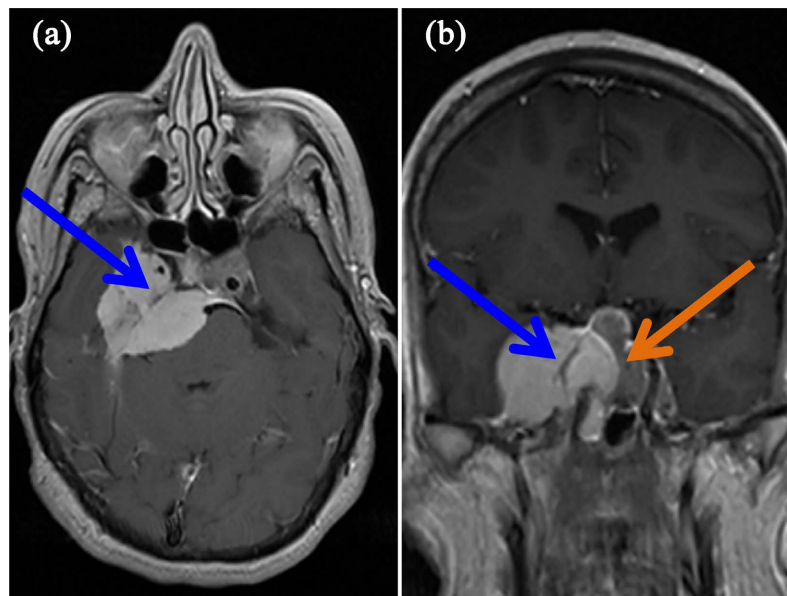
Cerebral MRI T1 axial with Gado (a), coronal slice (b) showing an extra-axial right temporal lesion—Meningioma (Blue arrow) extending to the cavernous lodge, with tissue signal, isointense in T1, intensified intensely after injection and a 2nd juxtaposed to a sellar-suprasellar seat lateralized to the left—Pituitary Adenoma (Red arrow).
